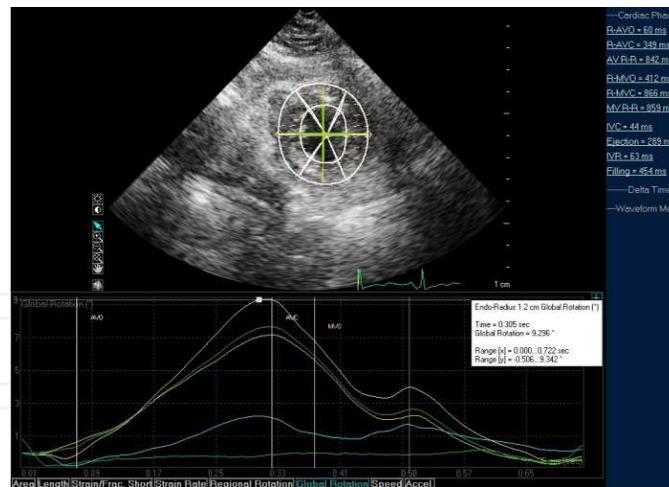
Rotation by speckle tracking echocardiography. The curves represents rotation in subendocardial, mural and subepicardial layers at the apical left ventricular level from parasternal short axis view.
